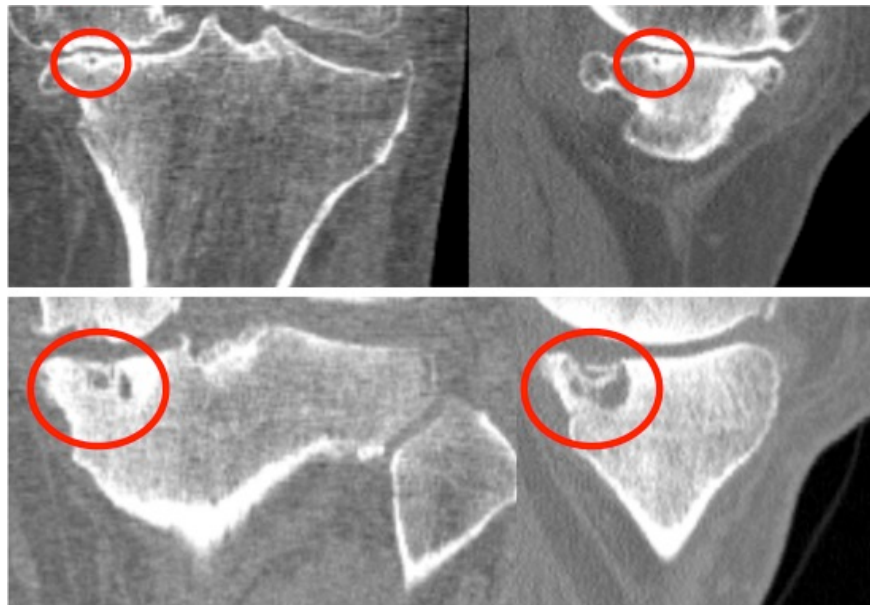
Sample CT images in coronal (left) and sagittal (right) views of OA patient with mild subchondral cysts (top row) and severe subchondral cysts (bottom row).
